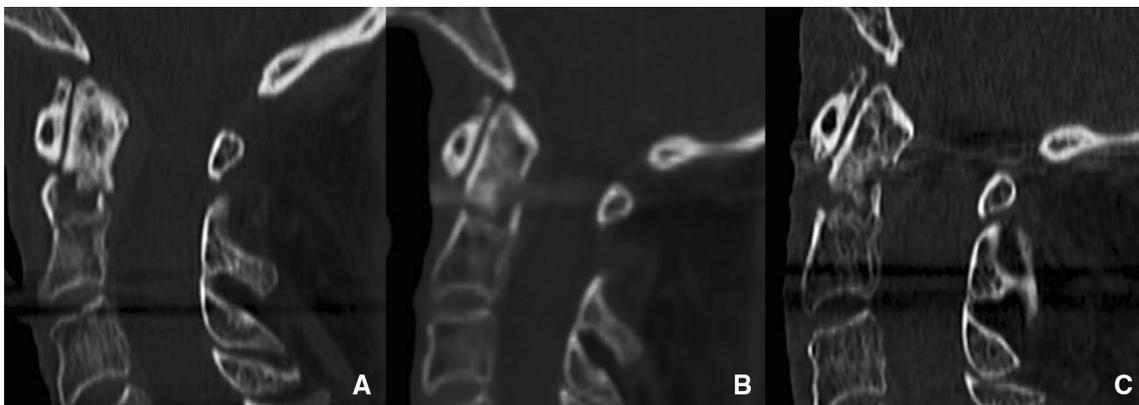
Evolution of non-union of a geriatric type II odontoid fracture: post-traumatic (a), 3 months (b) and 6 months (c) CT scan
